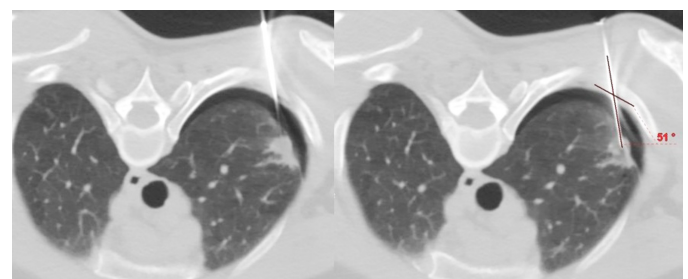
TTNB CT image of upper lobe and peripherally located lesion. The biopsy was performed in prone position and the needle was inserted medial to the scapula at an acute angle to the pleura due to superposition. Mild PTX developed when the needle was inside. Needle-to-pleural measurement is also shown.
